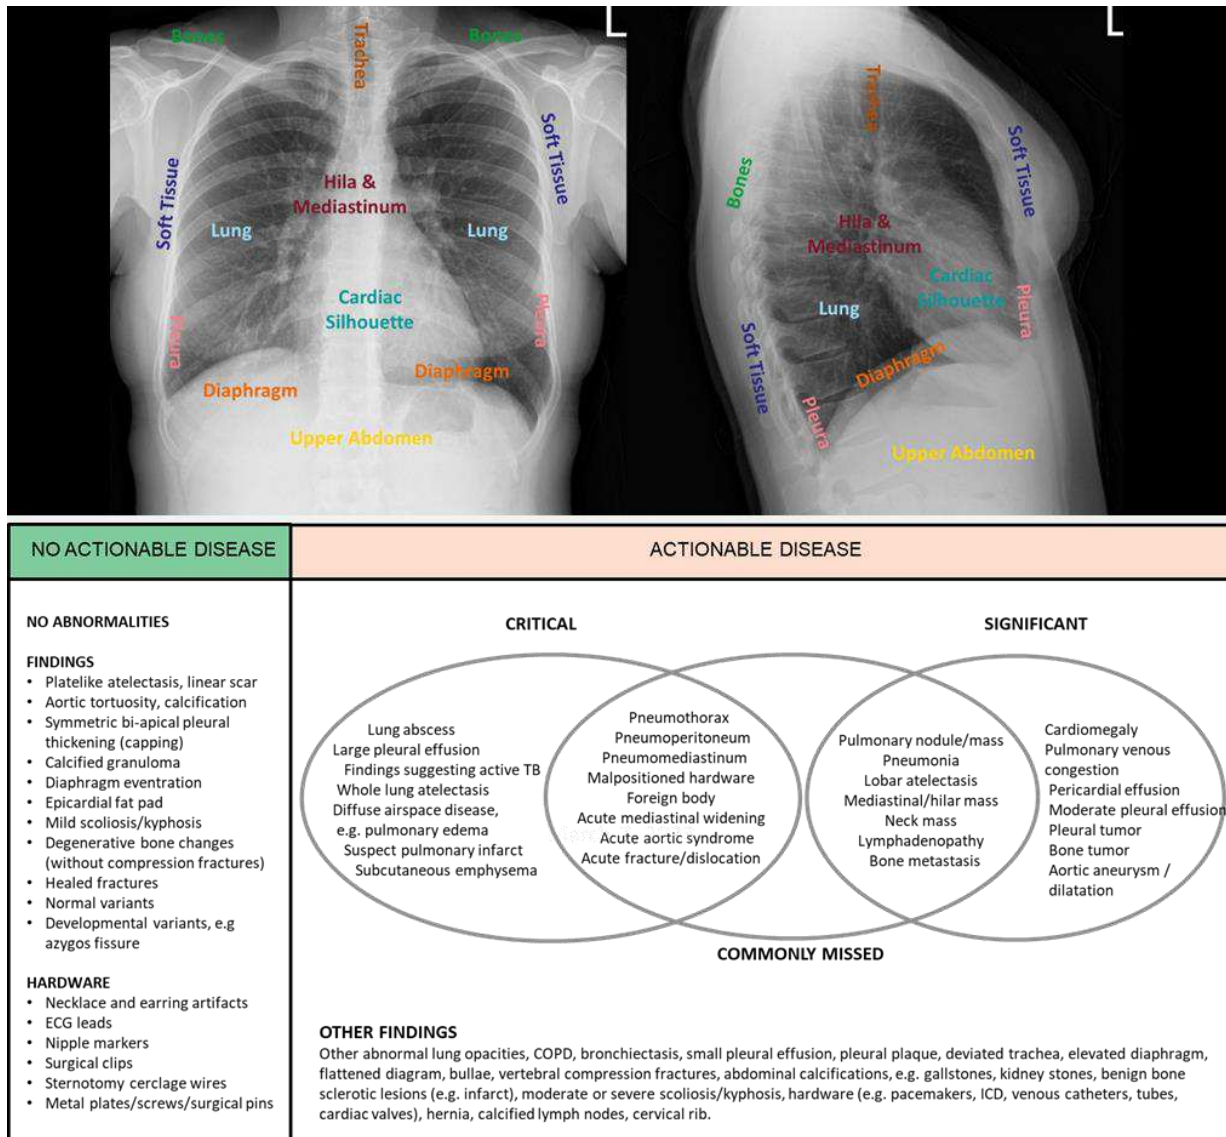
Criteria for no actionable disease (NAD) and actionable disease (AD) covering all compartments in chest radiographs.
